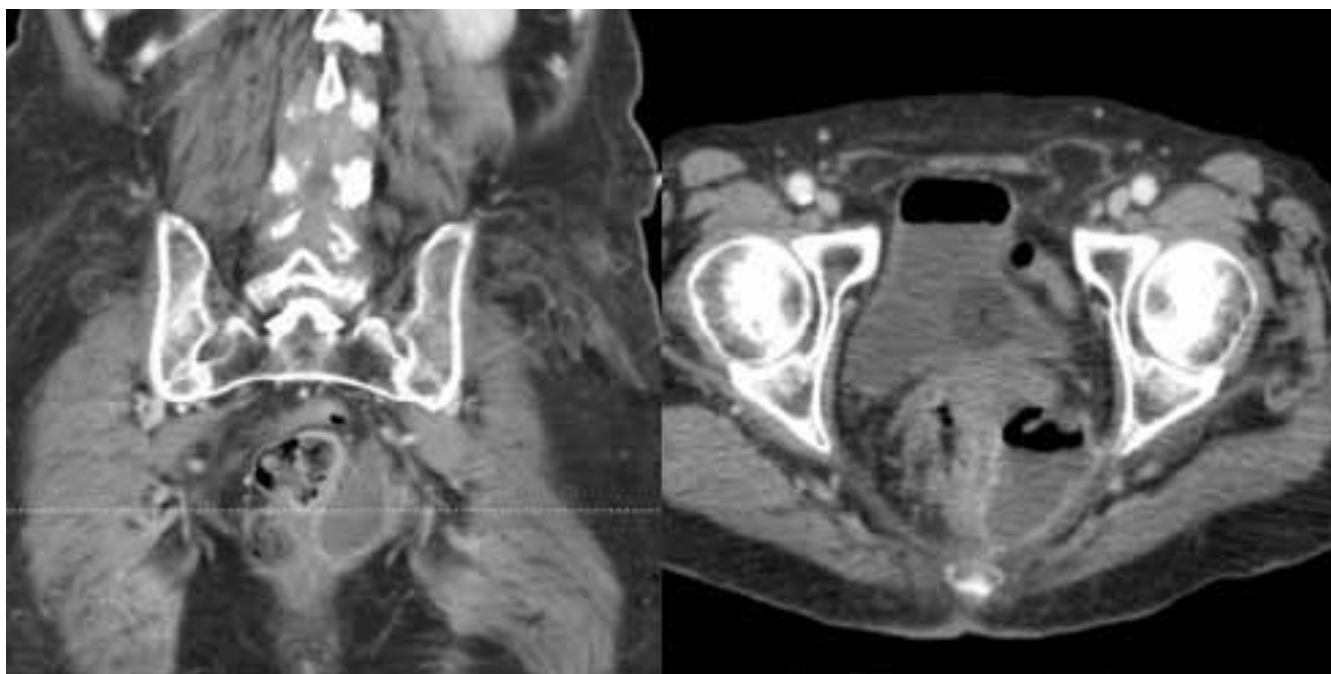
Frontal and axial CT revealed an encapsulated fluid collection in the pouch of Douglas.
